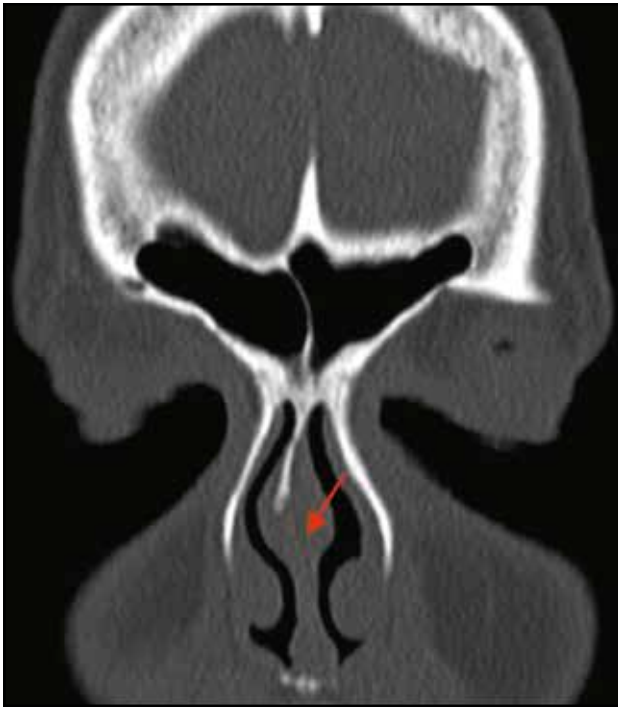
Cranio-facial CT scan, coronal section – Bilateral nasal swell body, with greater size on the left side (opposite to the right high septal deviation).
